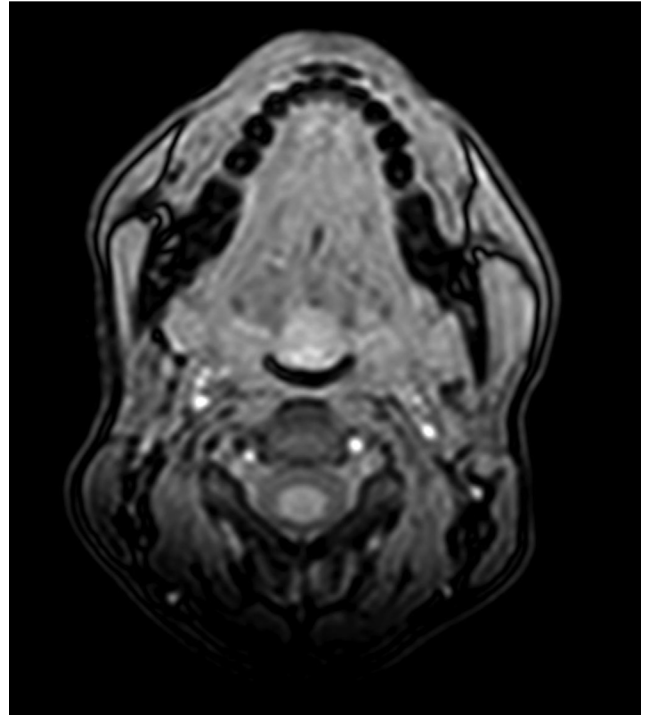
Magnetic resonance imaging THRIVE sequences on the axial plane, showing early vascularization of the ectopic thyroid tissue after gadolinium injection.
